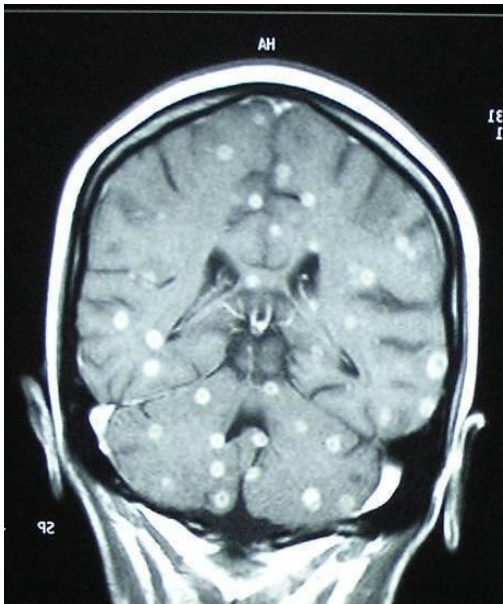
MR imaging of the brain, T1W1, post contrast (coronal view) shows multiple small ring enhancing lesions involving the cerebrum, brain stem, pons and cerebellum.
